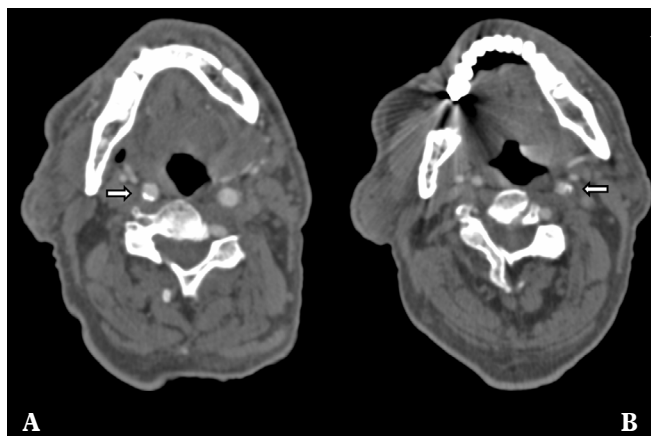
Computed tomography angiography of intracranial arteries: (A) a calcific plaque of right common carotid; (B) several calcific plaques of left internal carotid.
